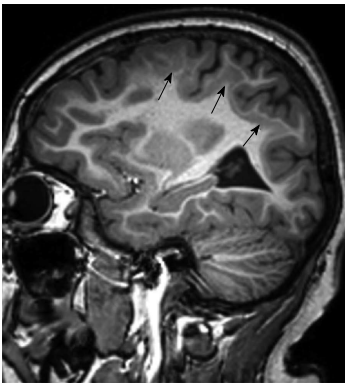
An 8-year-old girl with subcortical heterotopia. Sagittal 3D T1-weighted image shows band heterotopia (double cortex) located between the ventricular wall and the cerebral cortex (arrows).
